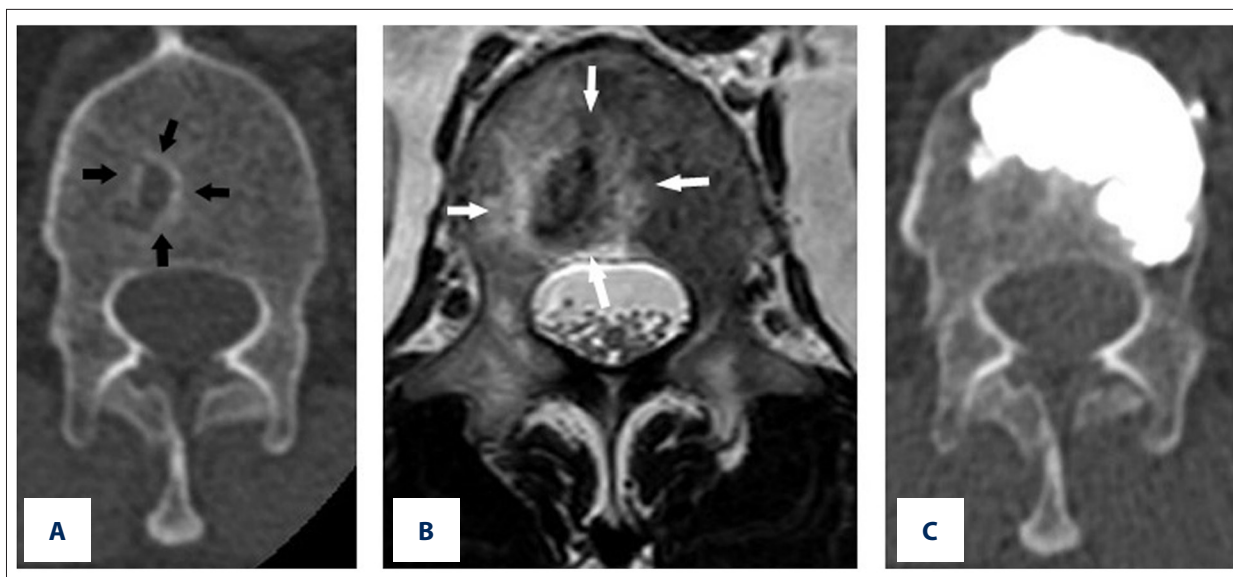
(A) Pretreatment axial CT demonstrates a Schmorl's node (black arrows) in L1 vertebra with surrounding sclerosis. (B) Pretreatment axial MRI (STIR sequence) in symptomatic L1 vertebrae shows hyperintense in the vertebrae bone marrow around the SN (white arrows point at the edematous rim around the node). (C) Postprocedural CT demonstrates PMMA cement filling the L1 vertebrae around the Schmorl's node without extravasation into the node.
